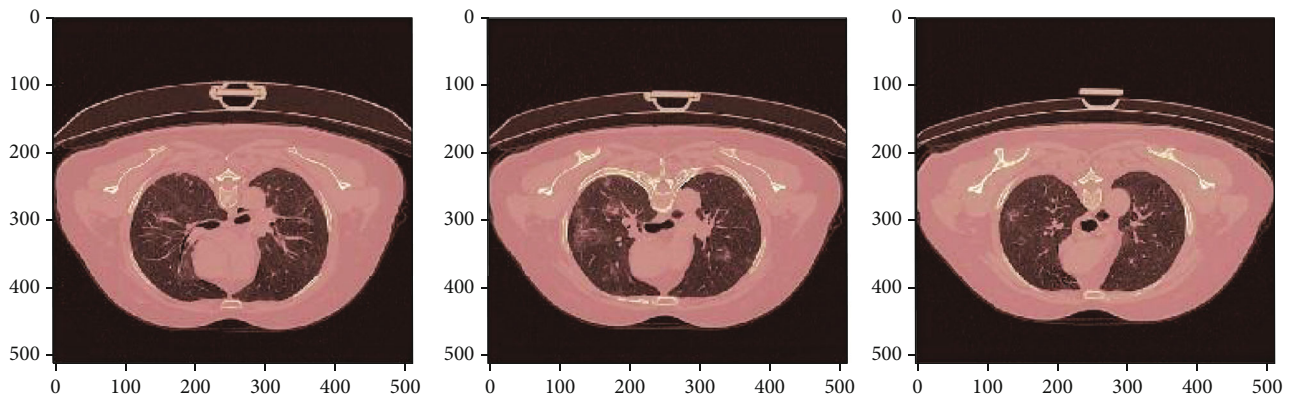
Colormap for normal chest CT scan images correctly classified by AlexNet+SVM and AlexNet+Random Forest.
